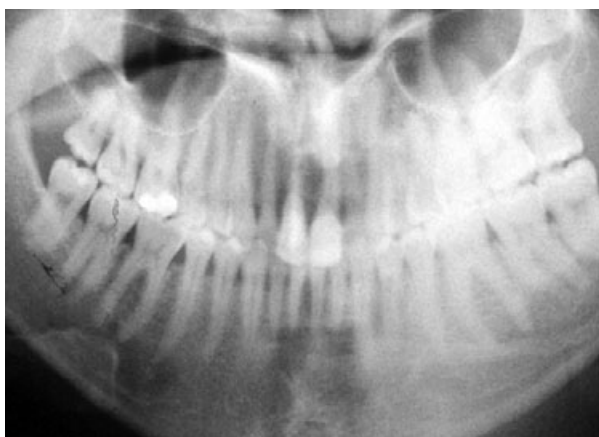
The radiographic view of the patient after treatment.
